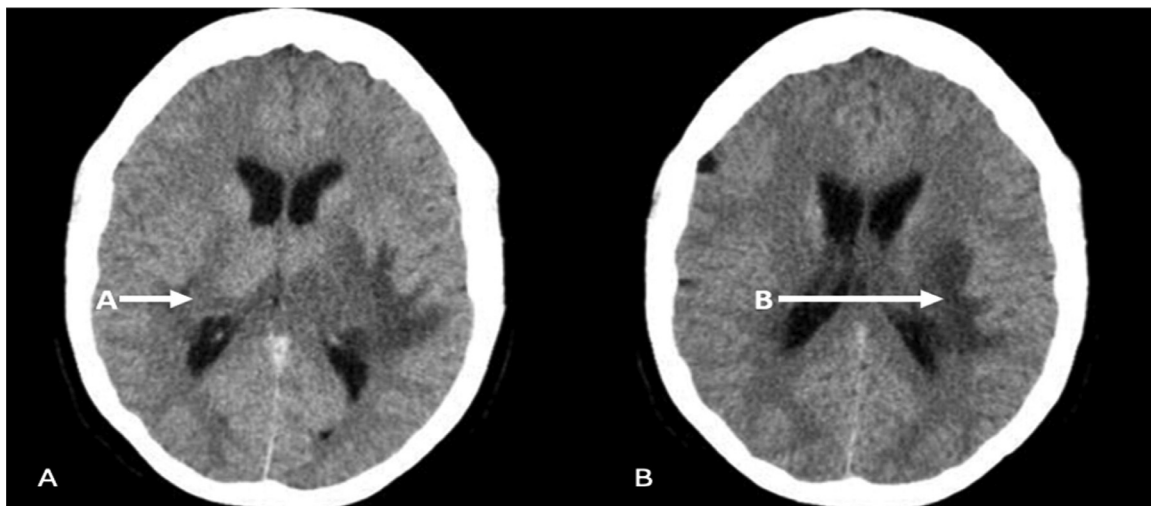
Admission CT Lesions in bilateral basal ganglia of left predominance, associated with left ventricular collapse towards midline. (A, B) Computed tomography.
